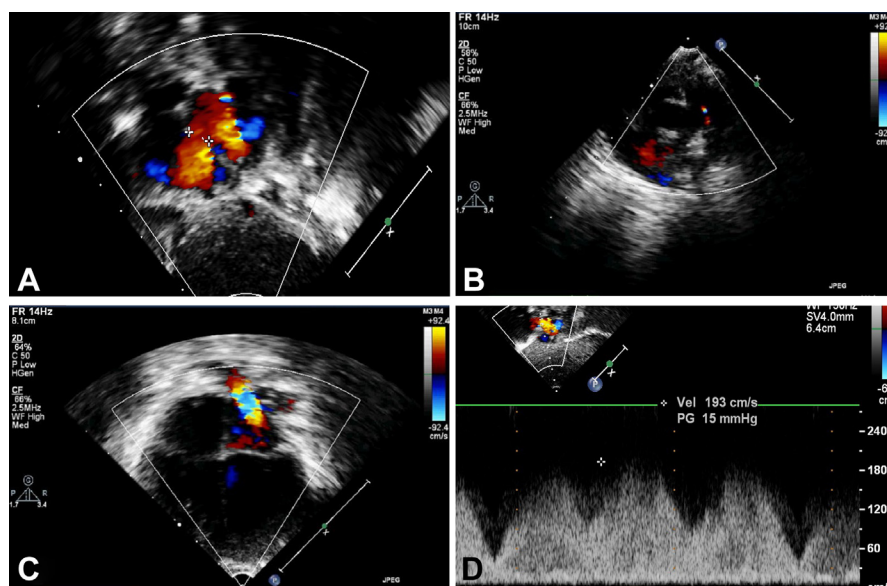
(A) The two atrium view showed atrial septal defect (right to left shunt) with color Doppler. (B) The two atrium view showed atrial septal defect (left to right shunt) with color Doppler. (C) The four chamber view showed normal blood reflux in right upper pulmonary vein with color Doppler. (D) Right upper pulmonary vein blood flow velocity demonstrated by continuous wave Doppler. (E) Left upper pulmonary vein blood flow velocity demonstrated by continuous wave Doppler. (F) Left down pulmonary vein blood flow velocity demonstrated by continuous wave Doppler.
